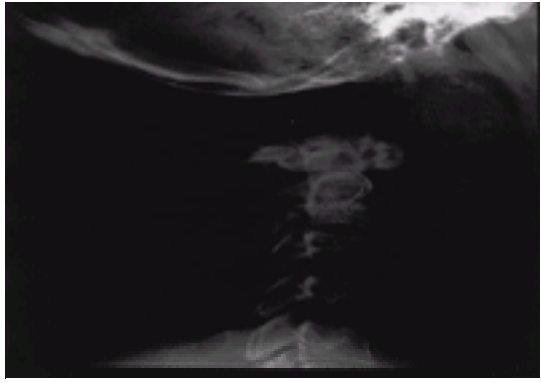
Radiograph of occipital–atlas displacement, almost always fatal.
